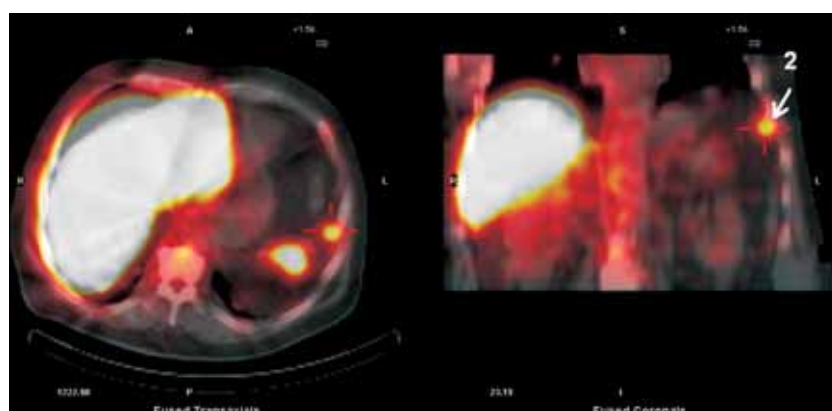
SPECT/CT images. Radiotracer uptake close to the chest wall.
